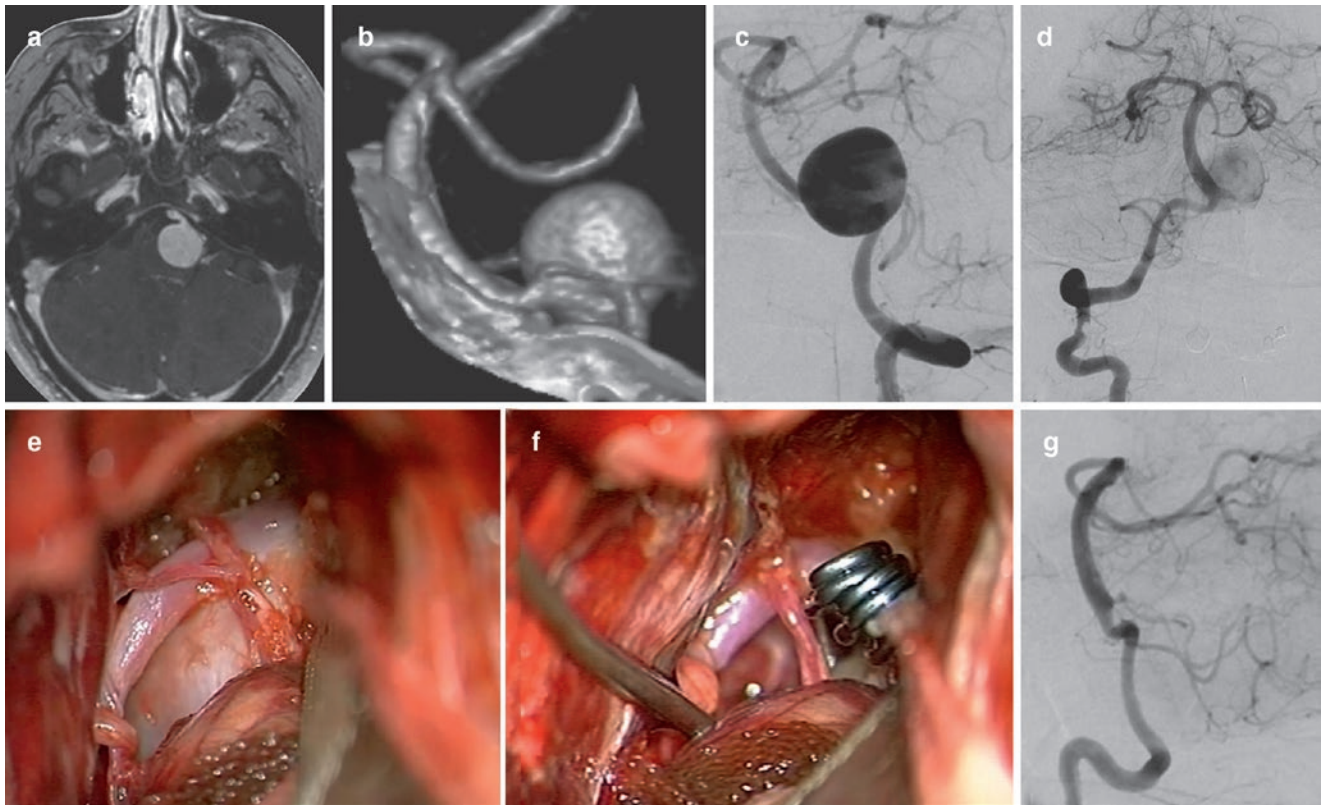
Contrast-enhanced MRI showing a left giant VA causing a brainstem compression (a). CT angiography and DSA demonstrating the involvement of PICA (b, c). BTO revealing no crossflow (d). Left
